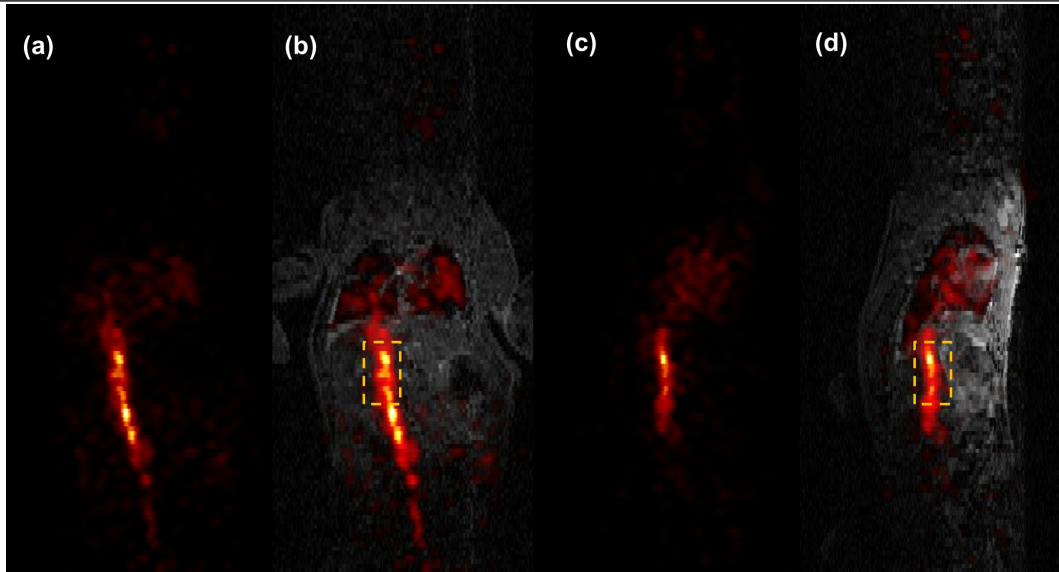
Location of vena cava ROI used to extract IDIFs on cardiac gated MAP images. Coronal view is shown in (a) PET data (early frame, 15s after injection, 5s duration) and (b) FISP MRI data with the sagittal PET view shown in (c) and the sagittal MR view in (d). Orange box indicates region of vena cava analyzed to attain IDIF estimate.
